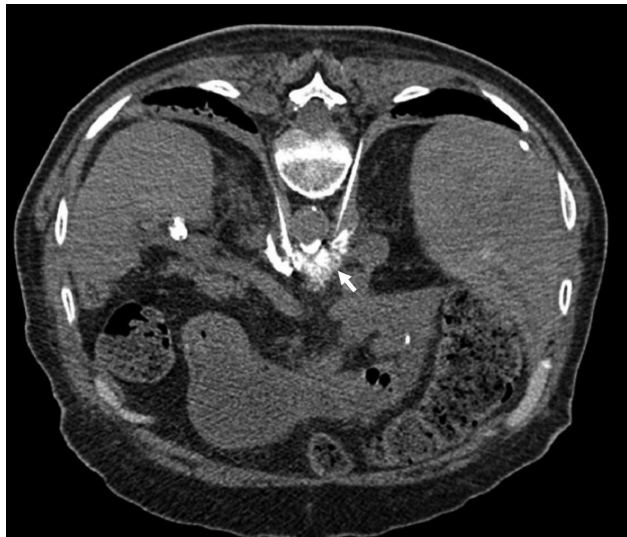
CT-guided alcohol celiac plexus neurolysis in a patient with metastatic pancreatic cancer. An intraprocedural noncontrast CT image through the celiac plexus demonstrates test injection (prior to alcohol injection) via bilateral 22-gauge Chiba needles of dilute iodinated contrast (small white arrow) with appropriate dispersion in the expected location of the celiac plexus.
